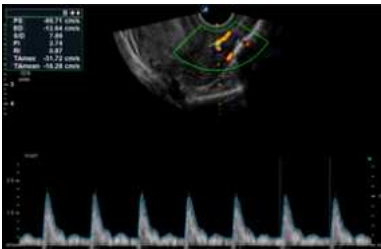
Transvaginal Doppler ultrasound image shows uterine artery flow with a Pulsatility Index (PI) of 2.7 in a 28-year-old female with a history of recurrent pregnancy loss. The spectral waveform reveals high-resistance flow with reduced diastolic component. These findings may suggest suboptimal uterine perfusion associated with impaired endometrial receptivity.
